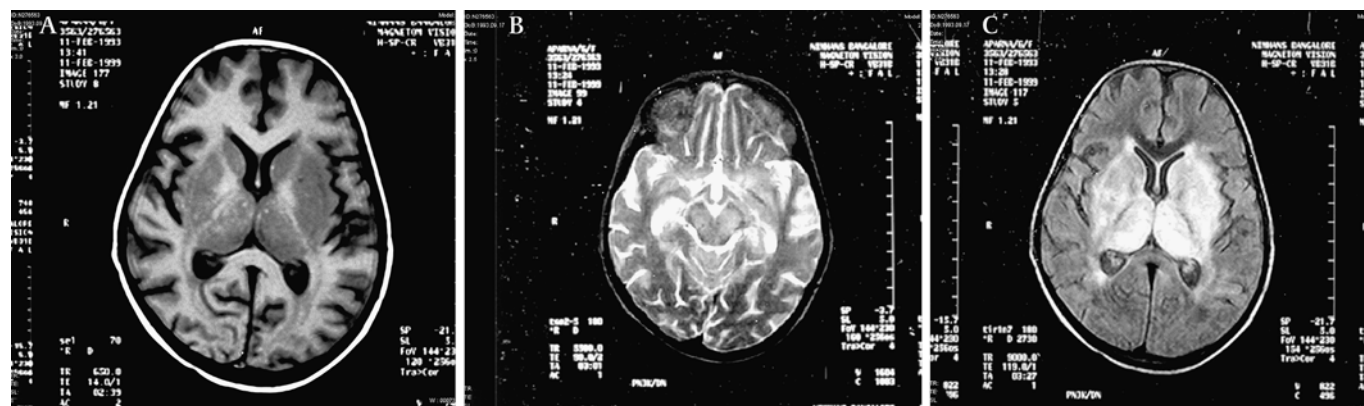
(A–C) MRI (brain): T1 weighted, T2 weighted and fluid-attenuated inversion recovery sequences show lesions in bilateral basal ganglia, thalami and cerebral peduncle which are hypointense on T1 and hyperintense on T2 and fluid-attenuated inversion recovery sequences (case 27, 6 years/female, paralytic rabies, duration of illness 14 days).
